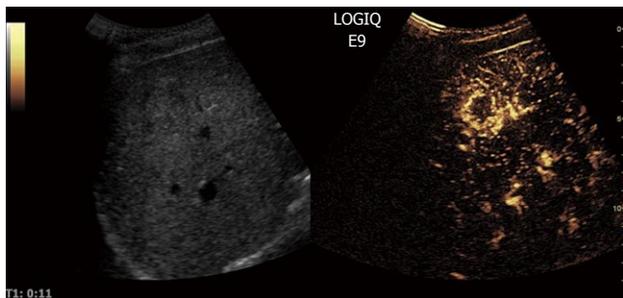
Contrast-enhanced ultrasound allows for visualization of the arteriogram of hepatocellular carcinoma in the early arterial phase. The feeding vessel is visible on the tumor right side. Typically there is initial peripheral enhancement before the centripetal influx to the center of the tumor.
